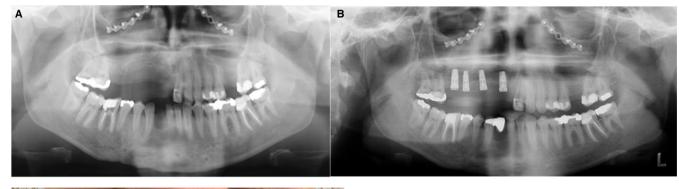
Dental restoration after a traffic accident with fractures of the mandible and the midface together with considerable bone loss in a 23-year-old female patient. (A) Panoramic X-ray showing the extent of bone loss in the maxilla; (B) Panoramic X-ray showing the site after insertion of dental implants; and (C) Clinical picture showing the final restoration.
